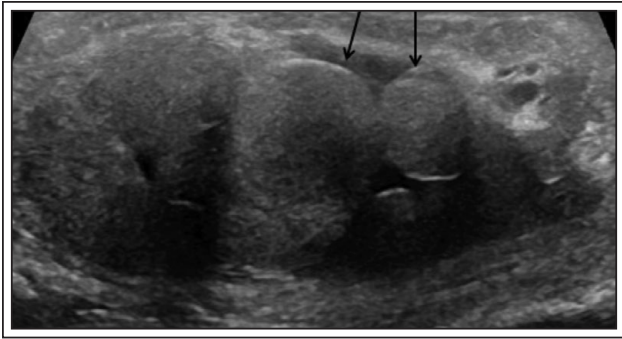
Scrotal ultrasound. Multiple extratesticular hypochoic mass-like lesions (arrows) with peripheral vascularity along the right epididymis.
